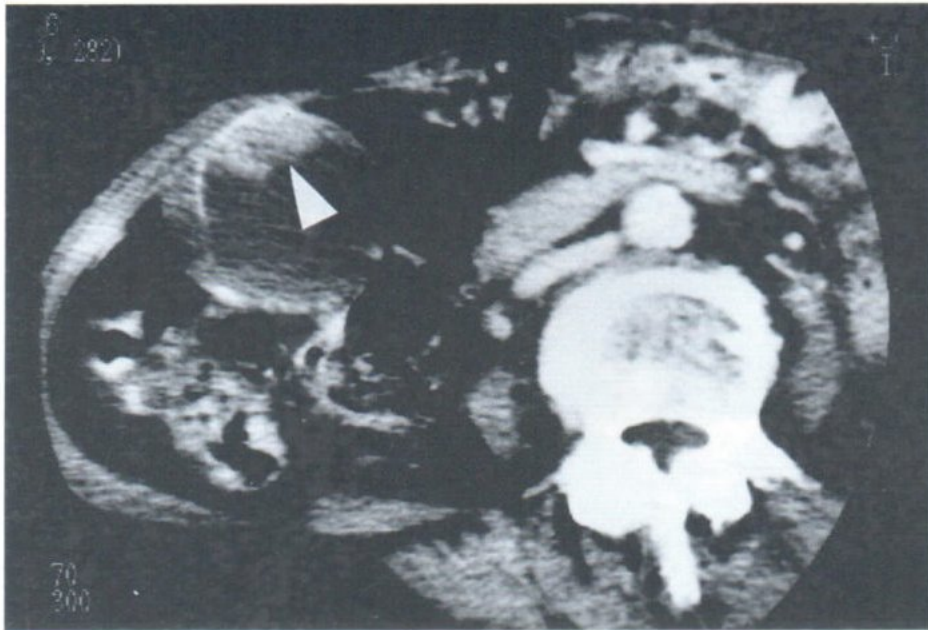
Papillary adenocarcinoma : CT post contrast enhancement of female 60 years old showed a small inhomogeneously enhanced polypoid mass (arrow) at the body of gall bladder.
